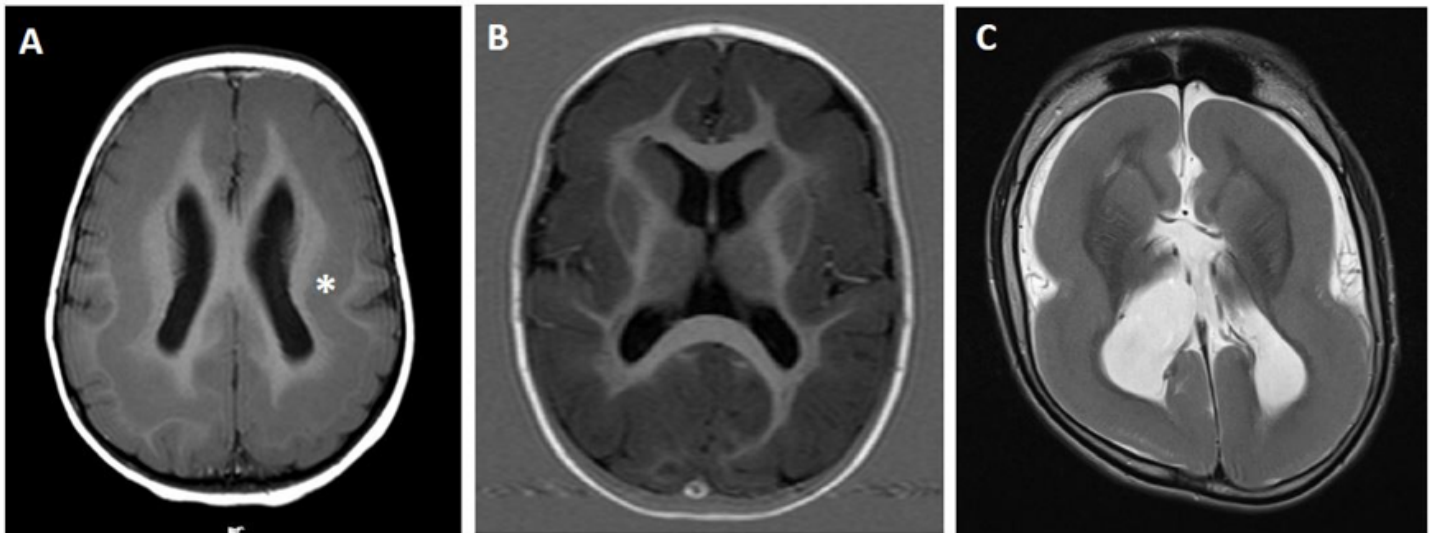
Cerebral MRI of three individuals with *DCX*-related disorders
